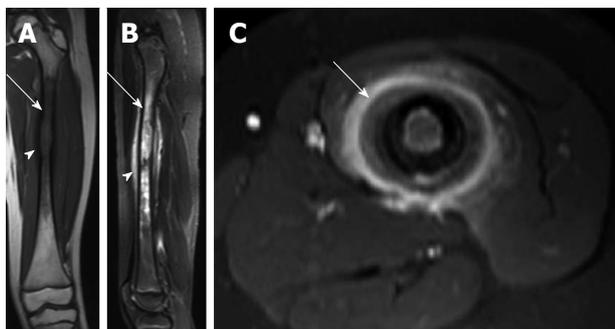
Langerhans cell histiocytosis. A: Coronal T1-weighted image of the left femur shows a long segment of marrow T1 hypointensity (arrow) and cortical erosion/expansion (arrowhead); B: Sagittal short-tau inversion recovery image from the same patient shows very intense T2-signal in the marrow cavity (arrow). T2 hyperintensity in the periosteum (arrowhead) is indicative of periosteal reaction; C: Axial T1-weighted image post contrast shows intense enhancement of the periosteum (arrow).
